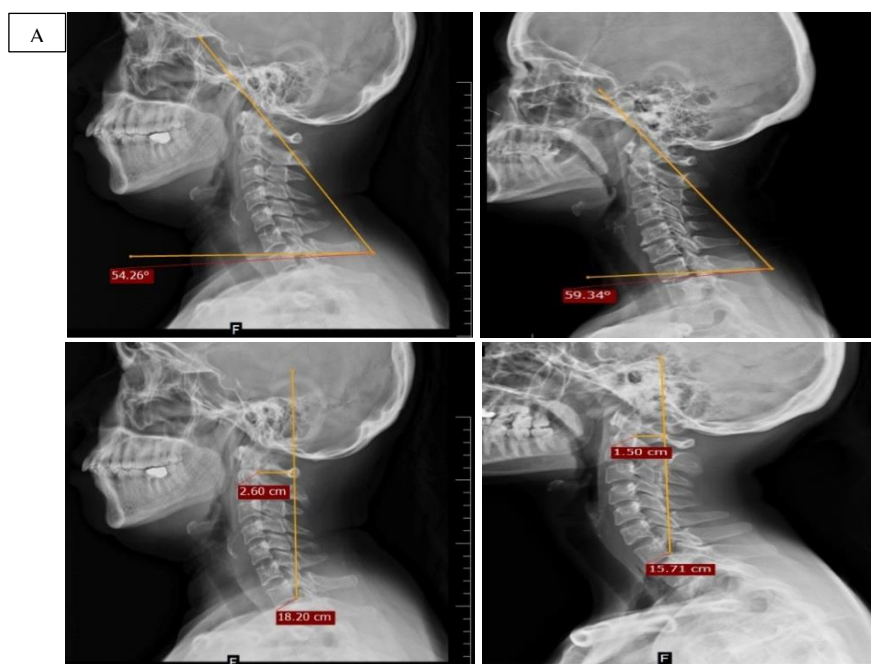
Lateral radiographs of the cervical spine and morphometric assessment. A) Craniovertebral angle (CVA) measurement; B) Anterior head translation (AHT)
